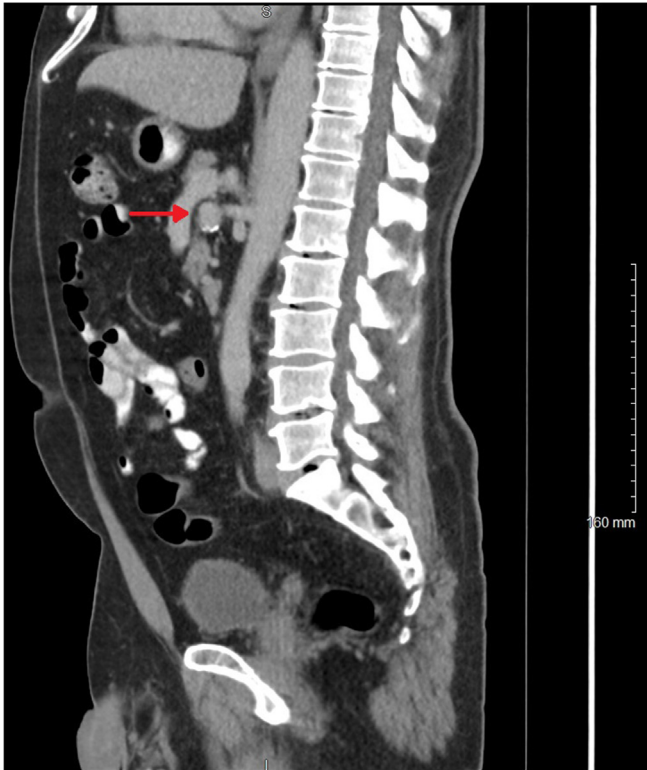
Computed tomography scan showing a 2.2-cm inferior pancreaticoduodenal aneurysm (arrow) adjacent to the superior mesenteric artery (SMA).
